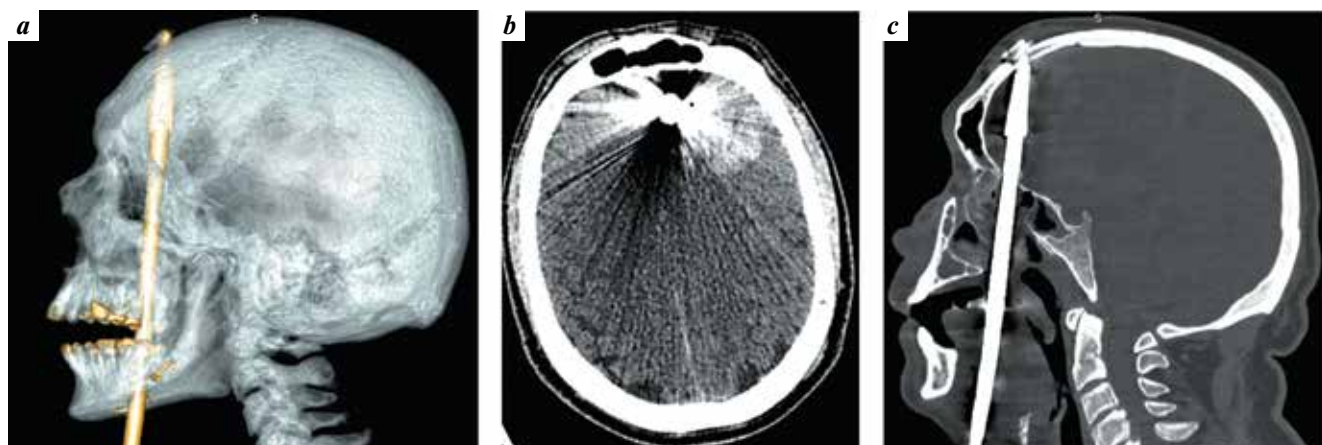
Computed tomography of patient G. at admission: a – 3D reconstruction: the massive harpoon tip with anti-passage “flags” is noteworthy; b – axial projection: intracerebral hematoma in the left frontal lobe; c – sagittal projection
